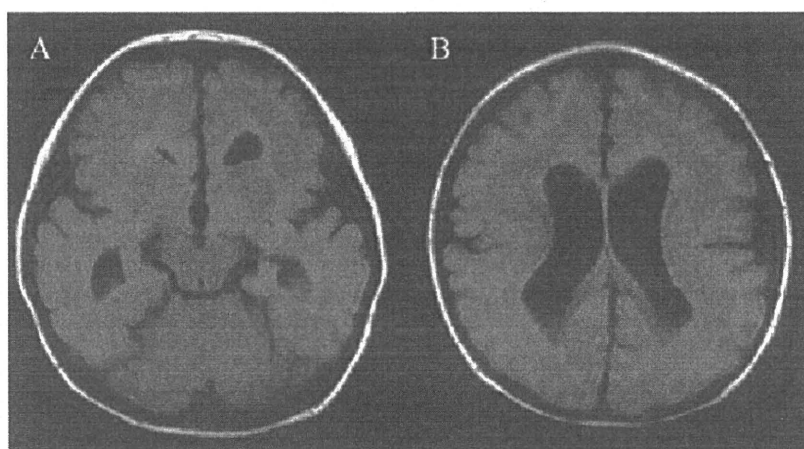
Axial T1-weighted magnetic resonance (MR) imaging
